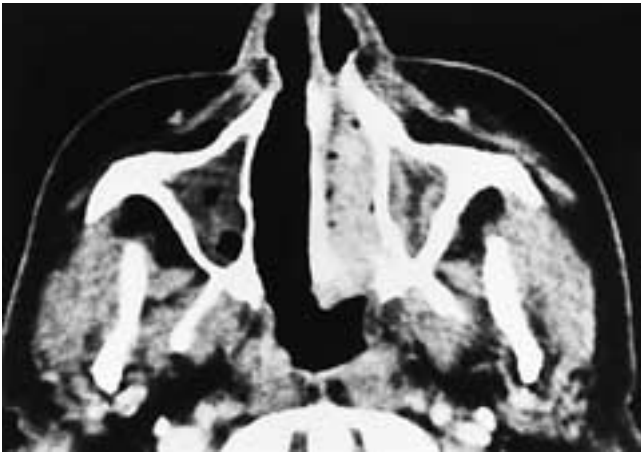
Axial contrast-enhanced CT scan shows an enhancing left nasal fossa polypoid mass. There are mucosal enhancement and secretions in the left maxillary sinus and mucoïd secretions in the right maxillary sinus. This patient had nasal polyps and sinusitis.
